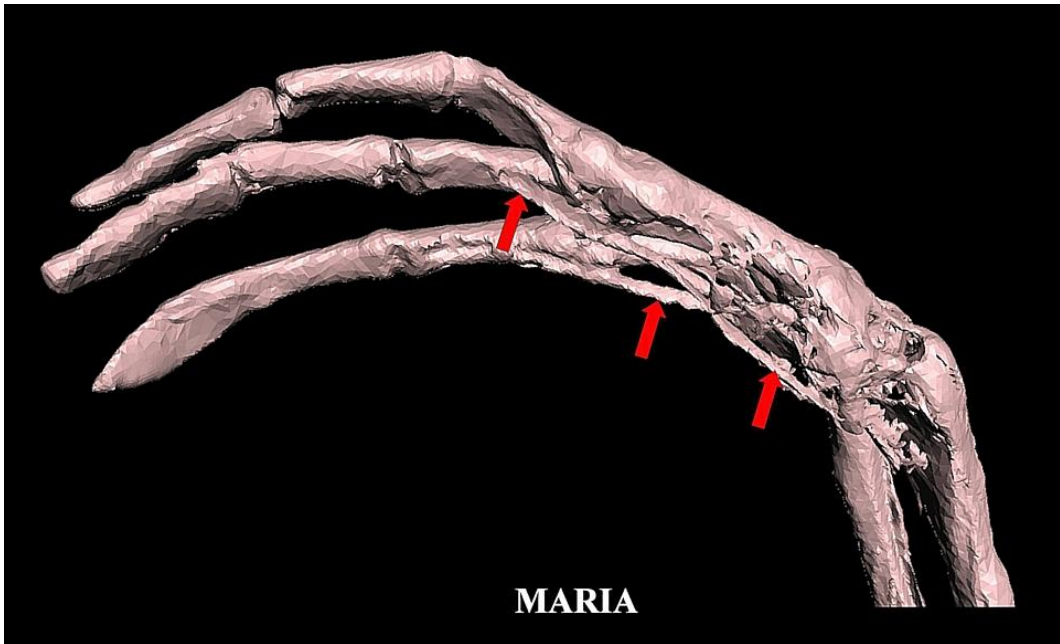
3D CT of right hand showing intact tendons and ligaments (*red arrows*).
